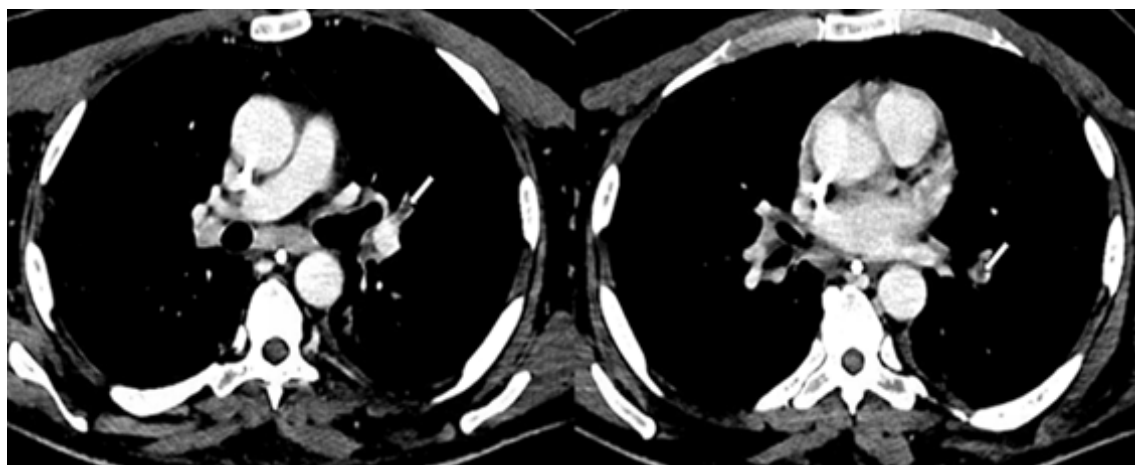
CT pulmonary angiography shows filling defects within the lingular and left lower lobe branches, suggestive of acute pulmonary embolism (arrows).
